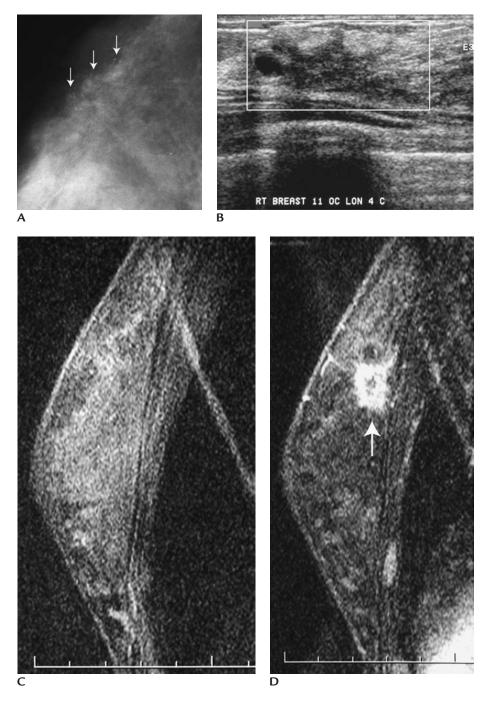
Tubular carcinoma. (A) Distortion with associated punctate and amorphous calcifications (*arrows*). Because DCIS, low nuclear grade cribriform type is found in as many as 65% of patients with tubular carcinomas, many of these lesions have associated punctate and amorphous, low density calcifications. (B) Irregular hypoechoic mass with spiculated, not well circumscribed (*box*) margins and associated high specular echoes consistent with the calcifications seen mammographically. (C) MRI. Pre-contrast sagittal T1-weighted image of the right breast. (D) Post-contrast image at the same table top as that in (C). Mass (*arrow*) with spiculated margins and rim enhancement. Portions of the mass demonstrate rapid initial enhancement with wash out of contrast.
